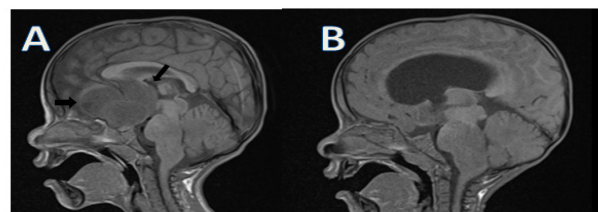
Cranial MR images of the patient before (A) and after treatment (B)
